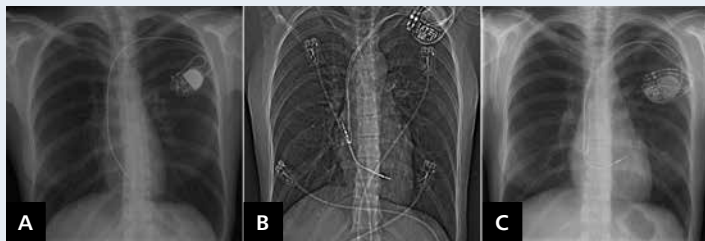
Chest X-ray in PA projection; A. VVI pacemaker; B. Perforating lead; C. Final pacemaker
